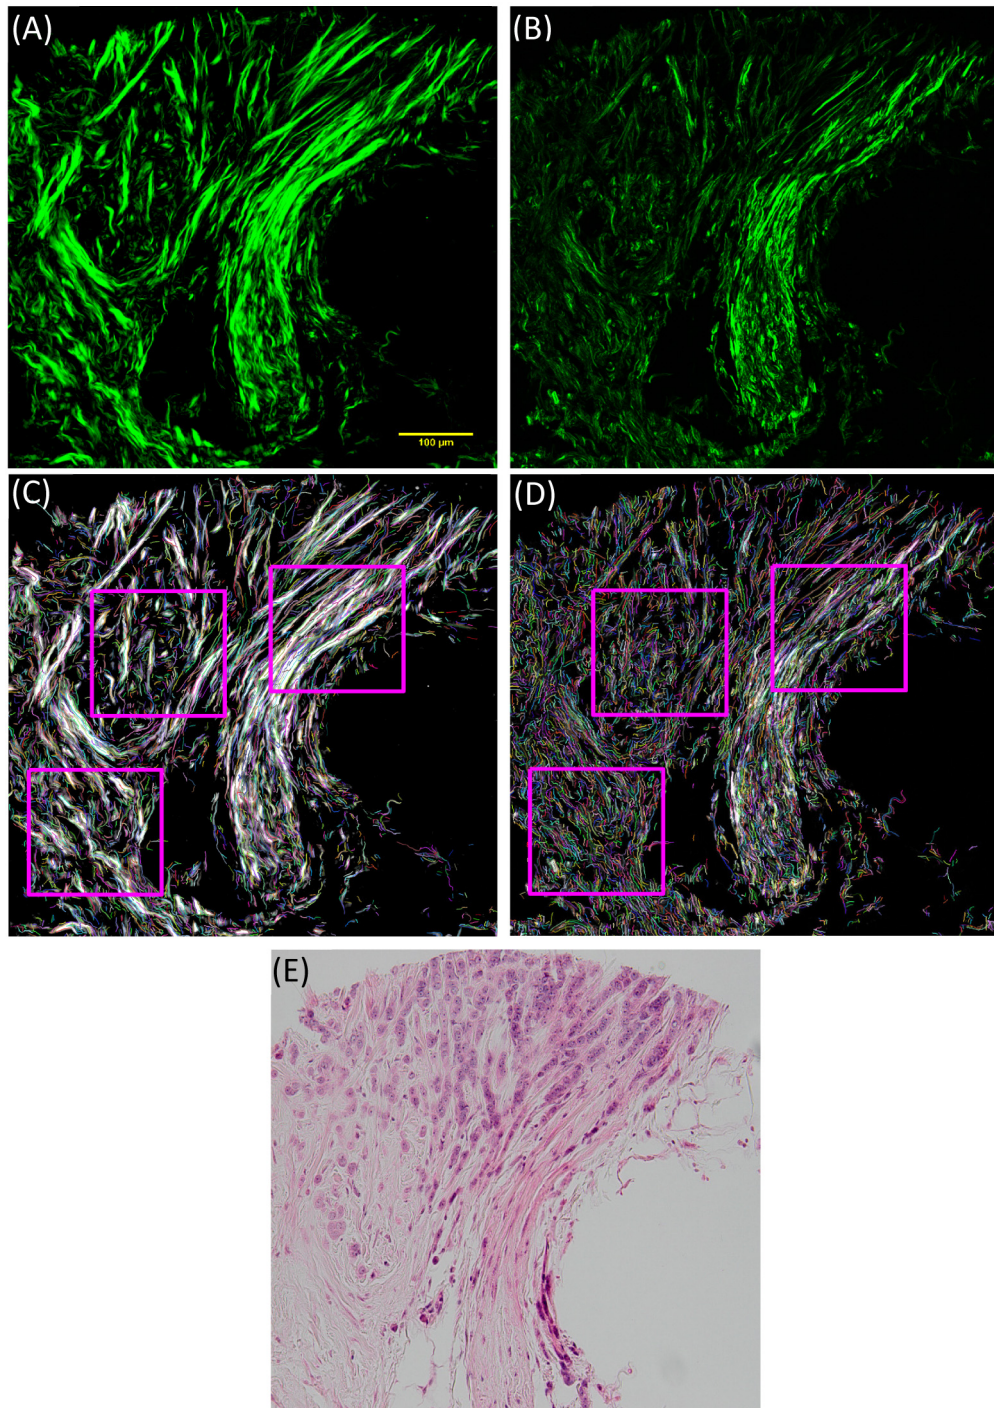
Comparison of LC-PolScope and SHG imaging on breast tissue slides. Breast tissue sample imaged with PolScope (A) and SHG (B). The CT-FIRE fiber detection results and ROI selection for PolScope (C) and SHG (D). Part (E) shows the bright field image of the same region. To be noted, CT-FIRE was run on the thresholded PolScope image as displayed in (A). The fibers in (C) and (D) are displayed in randomly selected false colors for visualization purpose. Brighter regions in (A) indicate thick or closely packed fibers.
